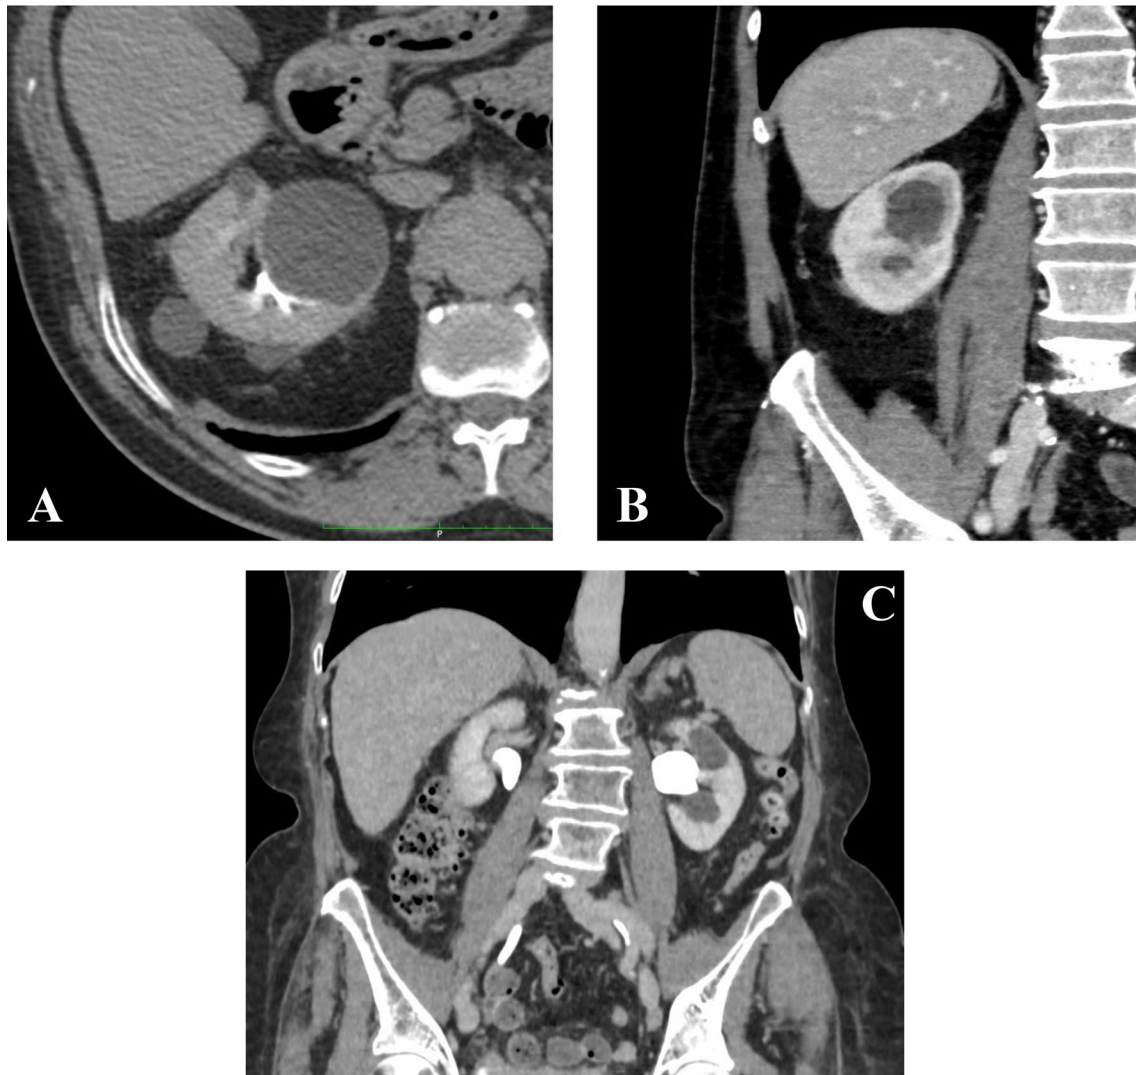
Evaluation of parapelvic cysts with computed tomography imaging
